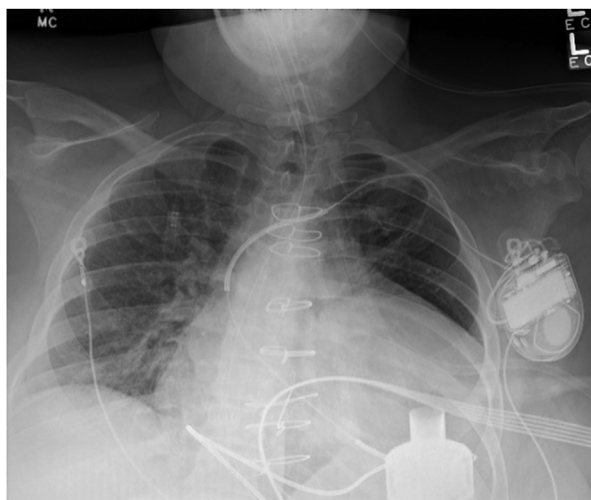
Radiograph of the donor's chest shows dilated heart with a HeartMate 3 device.
